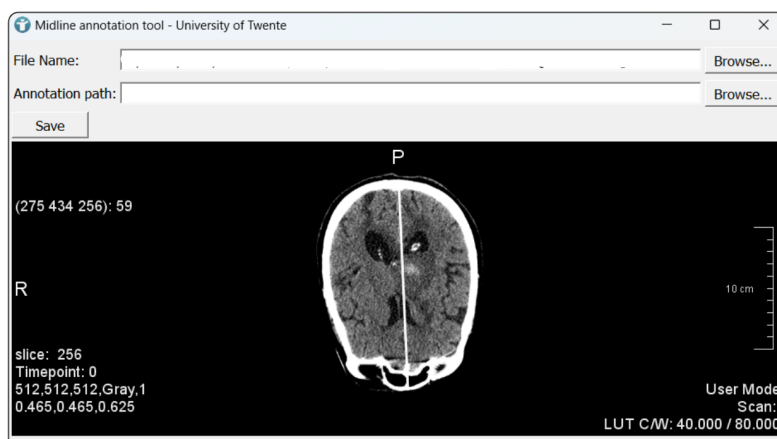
Annotation tool for annotation midlines on CT slices
